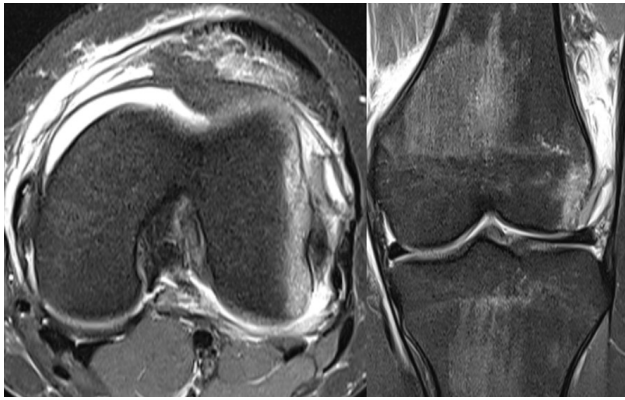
MRI Figures revealing lateral condyle edema and displaced injury.
